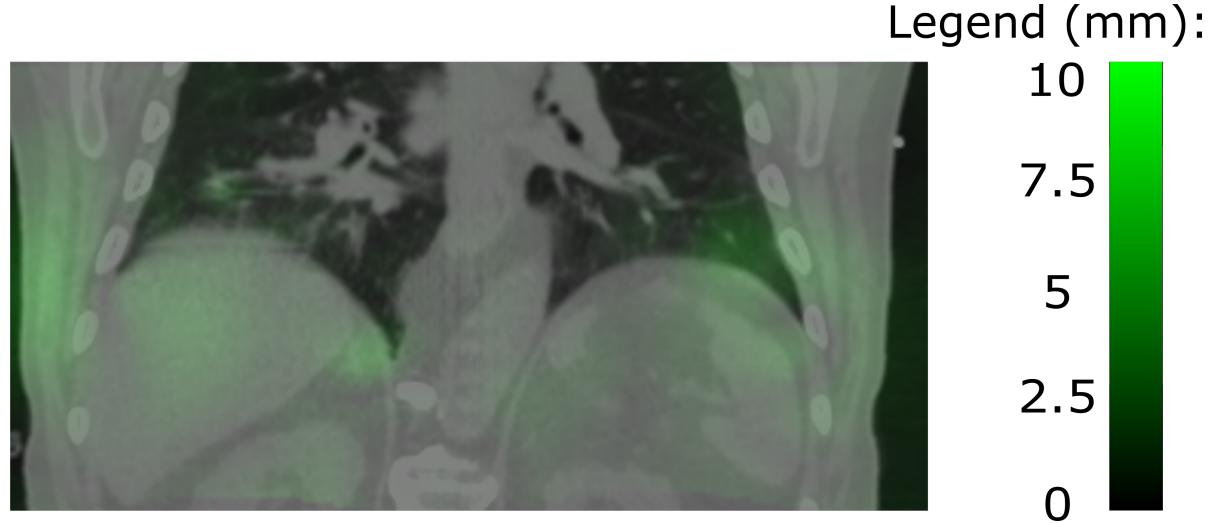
Image of inverse consistency error (ICE) overlayed on CT scan. The average value of displayed ICE is 1.0 with 0.7 STD. CHECK!
